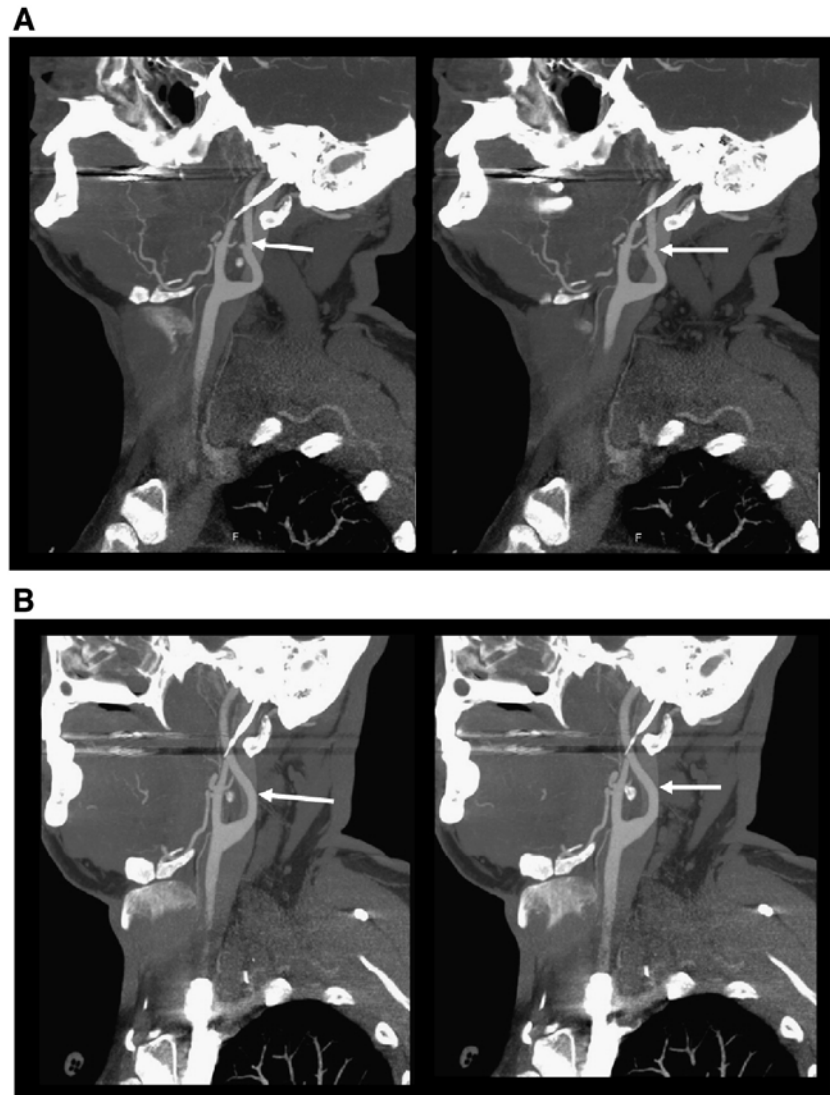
A. CTA demonstrates a left pseudoaneurysm on the extracranial internal carotid artery (arrow). This lesion is identified 8 weeks following injury. B. Resolution of the pseudoaneurysm after 6 months of anticoagulation. After this study, the patient was placed on aspirin monotherapy.
